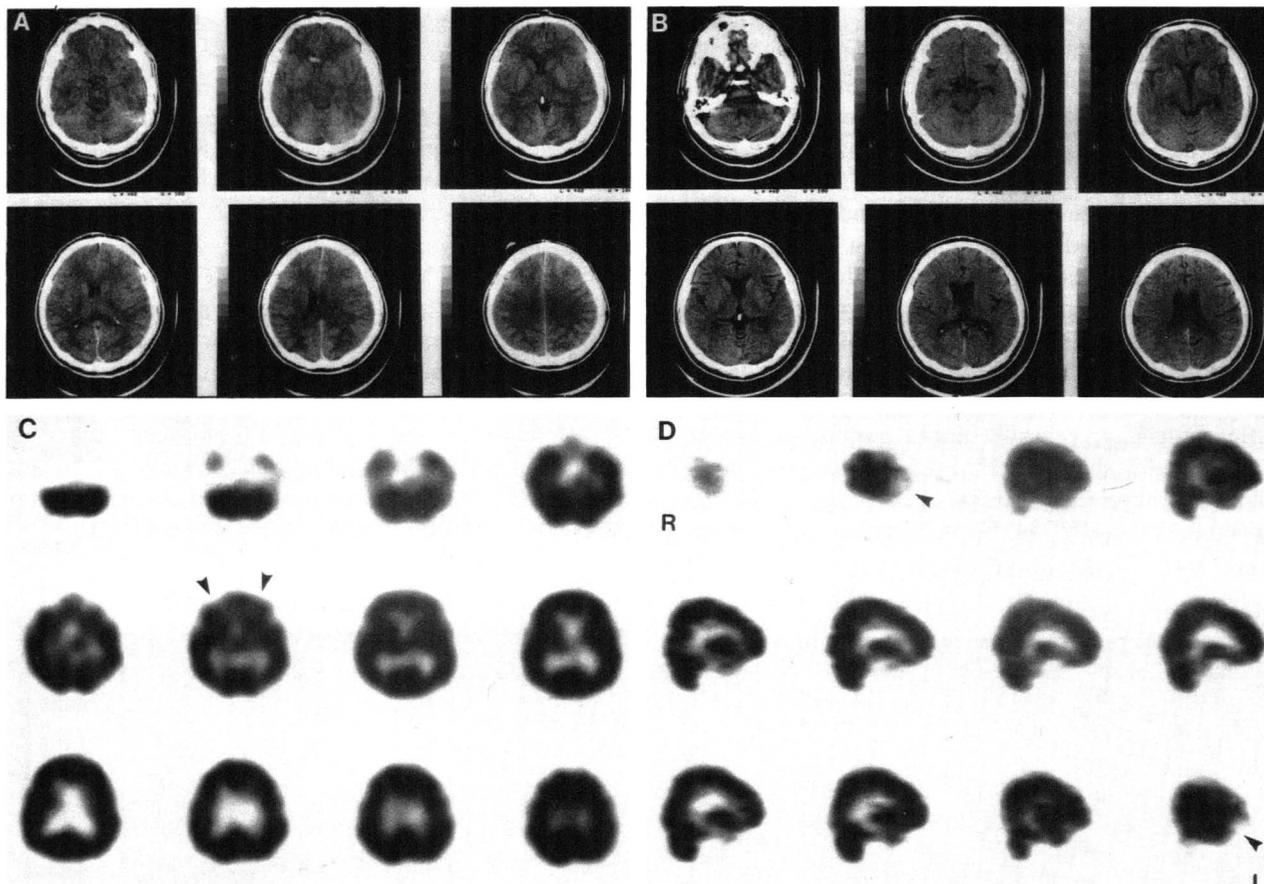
A 35-yr-old male who suffered a major head injury in a car accident. (GCS = 6 and PTA = 4 wk). Current symptomatology: headaches, cognitive deficits, and inability to cope. (A) Selected images from CT at time of trauma showed a small left subdural hemorrhage and intracerebral contusions located in the left frontal lobe and anterior forncus of corpus callosum. A mild mass effect is present. (B) Subsequent CT scan, 24 mo later, shows cerebral atrophy in the frontal and temporal lobes bilaterally (with left-sided predominance), as well as left parietal and occipital regions. HMPAO SPECT images, (C) transaxial and (D) sagittal, obtained 56 mo after trauma, show only minimal perfusion deficits in the inferior frontal lobes bilaterally (arrowheads).
